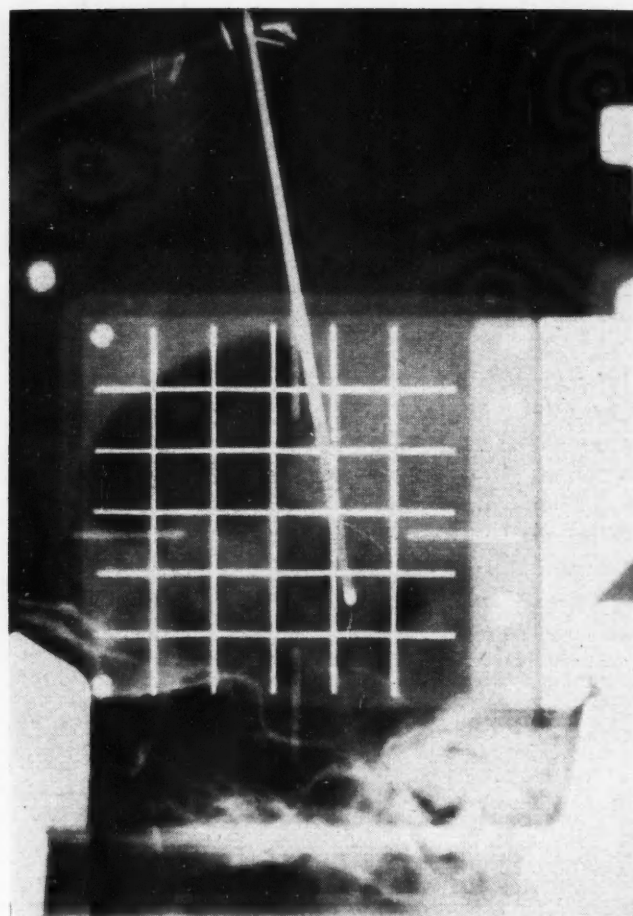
Photograph of x-ray showing leucotome in place of needle-electrode. Section is centred about the second contact above and in front of the point for motor face stimulation.
